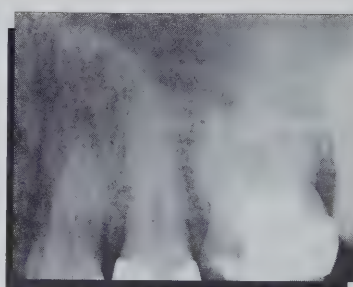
Maxillary periapical view of osteosarcoma demonstrating the appearance of calcification within the altered bone pattern.
